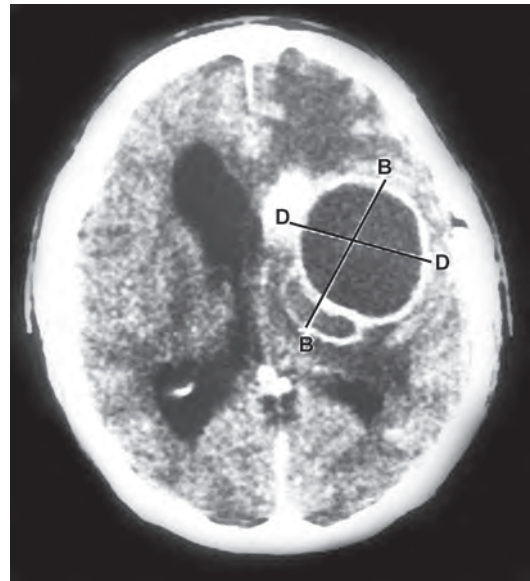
CT brain showing retained intracranial splinters with cerebral abscess
